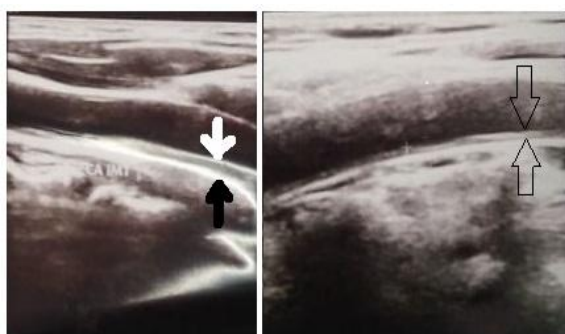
Common carotid ultrasound image showing significant intima media thickening of 1.26 mm (solid arrows) in a 52 year old male and insignificant 0.72 mm (hollow arrows) in 61 years old male.
